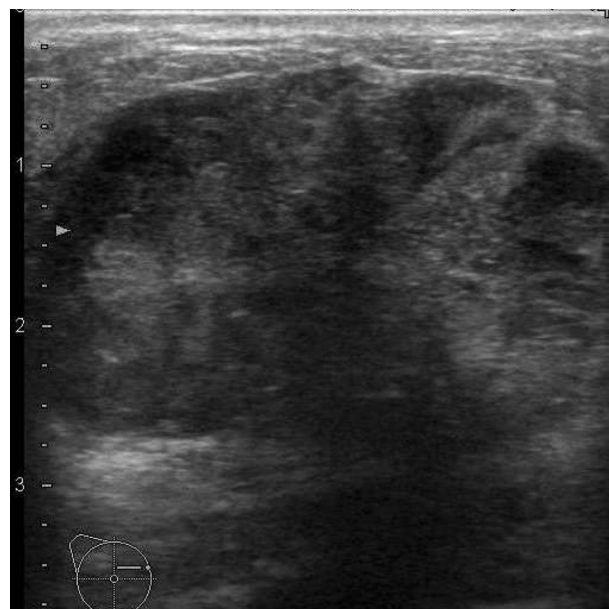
Ultrasonography showed an oval circumscribed heterogeneous solid mass parallel to the pectoralis major. The posterior features combined partial shadowing and enhancement.
